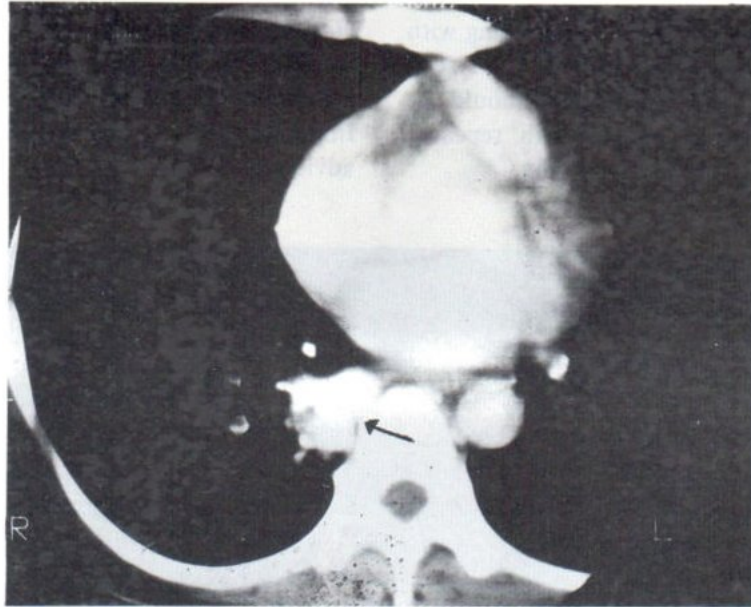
CT scan of thorax; (Fig. 11) at upper lobe level revealing calcified atelectasis of RUL; (Fig. 12) at hilar level showing calcified nodule (arrow) situating in superior segment of RLL.
